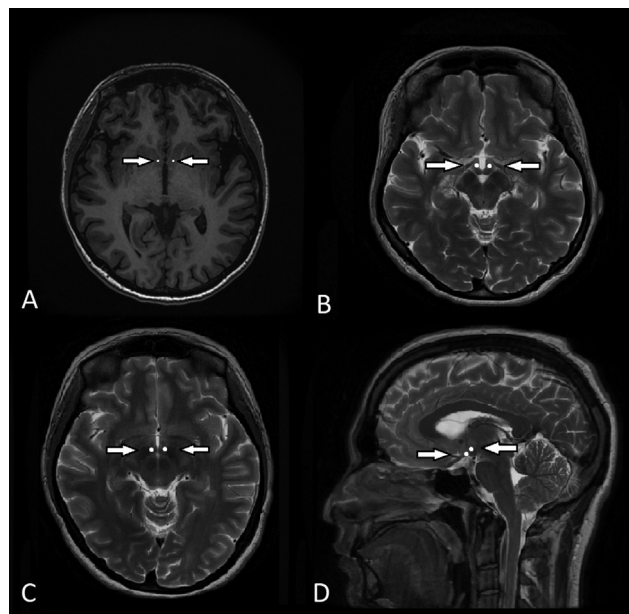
(A) The visualization of nucleus accumbens (NAc) in 1.5-T magnetic resonance imaging (MRI) T1-weighted image in axial orientation. The nucleus accumbens is marked on the image with white dots. NAc lies medial to the ventral capsule. (B) The ventromedial hypothalamus (VMH) presented on the axial 1.5-T MRI T2-weighted image lies posterior to the optic nerve, anterior to the mammillary body, and inferior to the anterior commissure. (C) The lateral hypothalamus (LH) is demarcated in 1.5-T MRI T2-weighted image in axial orientation. The LH is located superoposterior to the optic nerve and chiasma and inferior to the fornix. (D) The VMH and LH are marked on the sagittal image with white dots. The VMH lies medial and ventral to the LH. The arrows indicate the location of the white dots.
